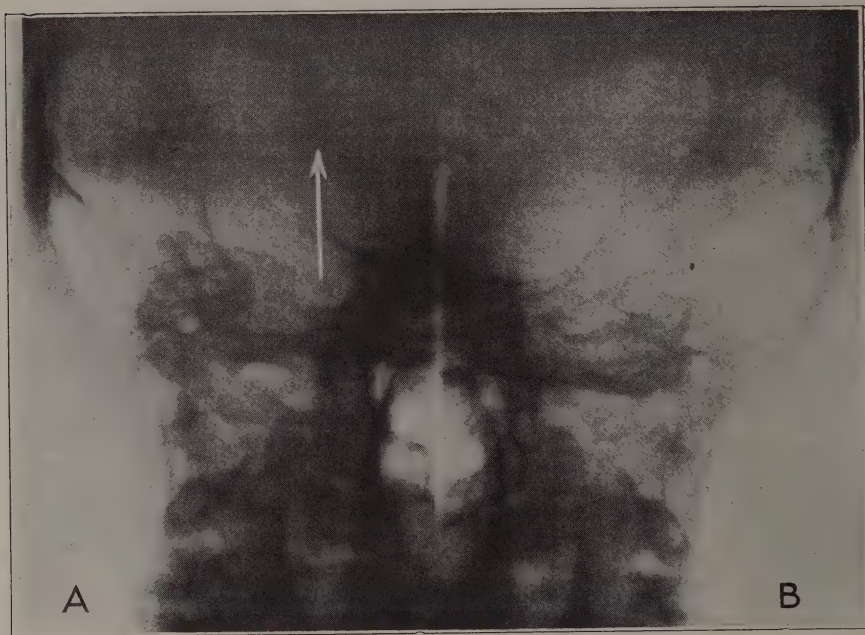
(Case 4). Roentgenogram showing haziness of the area of the apex tip and the perilabyrinthine area as compared with the same areas on the uninvolvement side.
